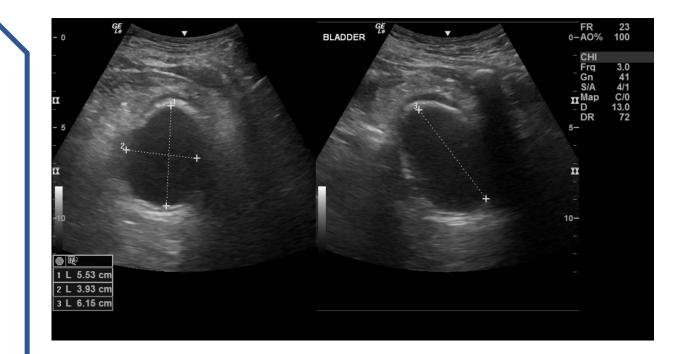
B-mode ultrasound images showing mural calcification of the urinary bladder.
